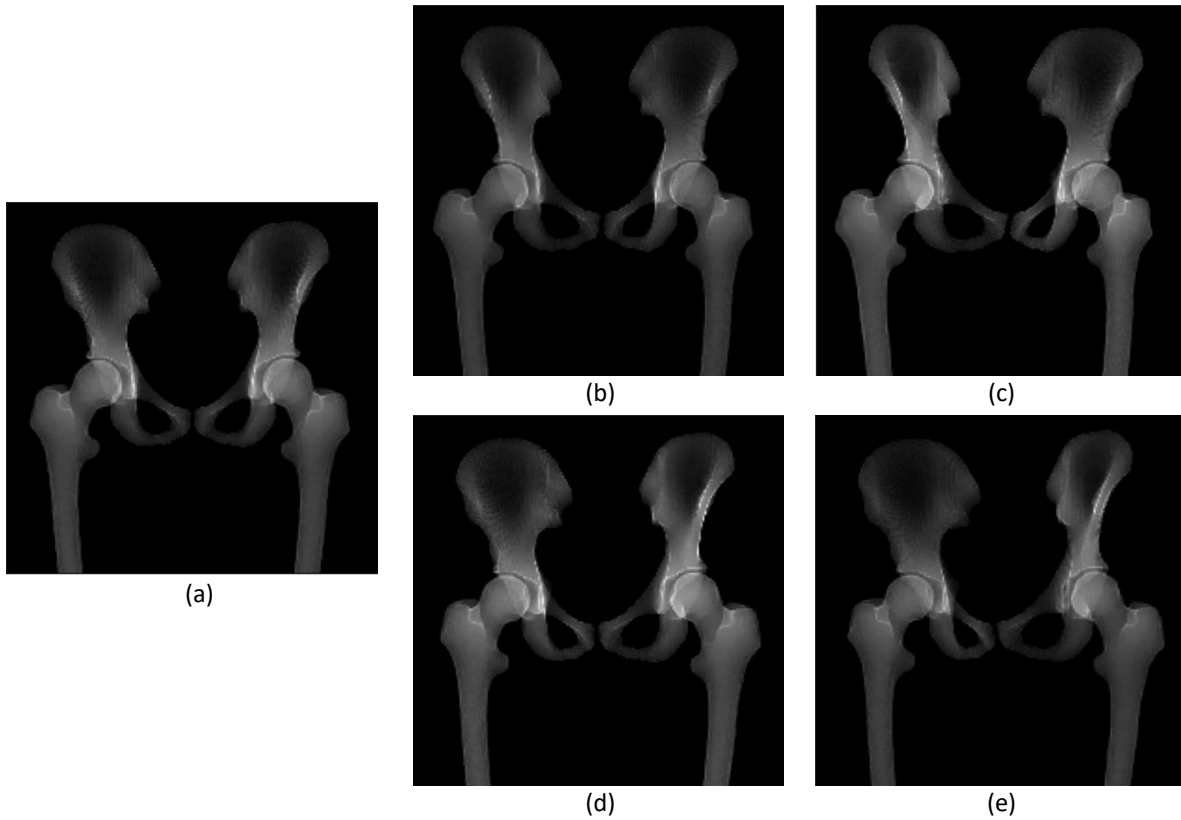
Rotated Digitally Reconstructed Radiographs (DRRs) of one participant. (a) DRR in neutral position ( $0^\circ$  rotation). (b) DRR with  $-5^\circ$  rotation. (c) DRR with  $-10^\circ$  rotation. (d) DRR with  $+5^\circ$  rotation. (e) DRR with  $+10^\circ$  rotation.
